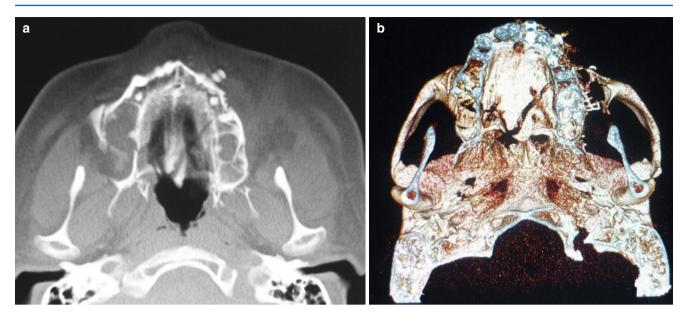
Similar views on axial (a) and three-dimensional (b) CT, showing palatal fracture. Note bowing of the zygomatic arch
